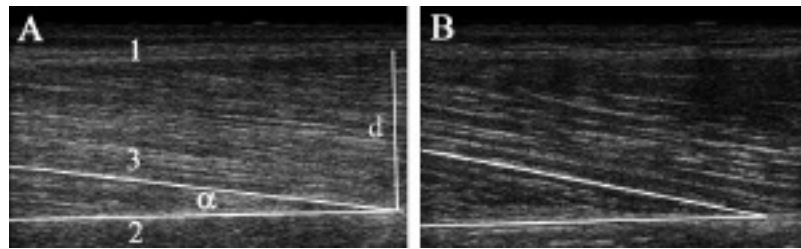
Sagittal-plane sonographs of the vastus lateralis (VL) muscle of a patient with rheumatoid arthritis (A) and a healthy control (B). Note the greater pennation angle in the muscle of the healthy control. 1: superficial aponeurosis, 2: deep aponeurosis, 3: fiber fascicles; the pennation angle α is the angle of insertion of the fiber fascicle into the deep aponeurosis of the VL. Fiber fascicle length (Lf) was calculated from the pennation angle and the muscle thickness (d) by the equation $Lf = d/(\sin)(\text{pennation angle})$.
